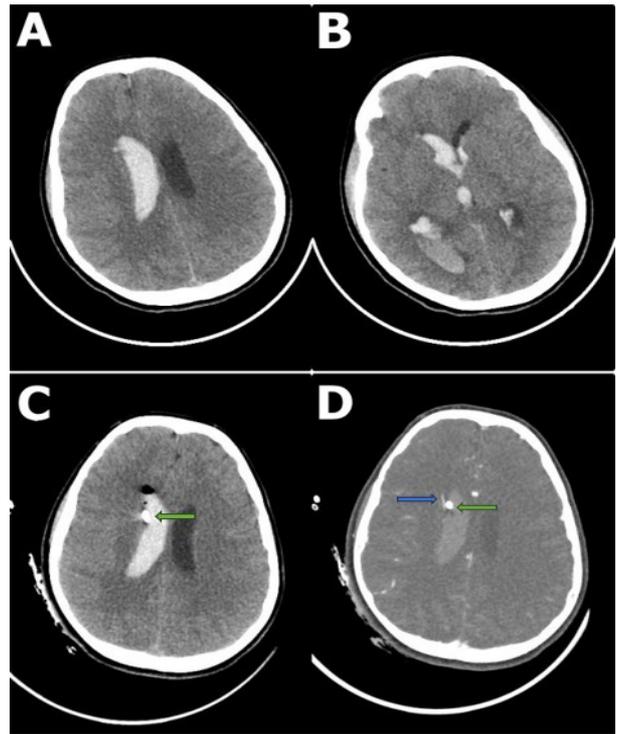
A, B: Preoperative CT scans demonstrating acute intraventricular haemorrhage. (C) Postoperative CT scan confirming persistent intraventricular haemorrhage with the EVD catheter (green arrow) positioned within the ventricle. D: Postoperative CT angiography revealing intraventricular haemorrhage, a suspected AVM nidus (blue arrow) at the head of the right caudate nucleus, and the close proximity of the EVD catheter (green arrow) to the AVM drainage vein within the ventricle
